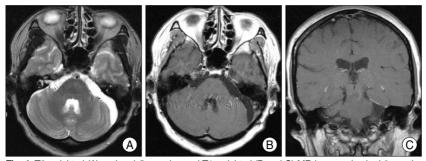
T2-weighted (A) and gadolium enhanced T1-weighted (B and C) MR images checked 6 months after the surgery show no remnant or recurrence.
